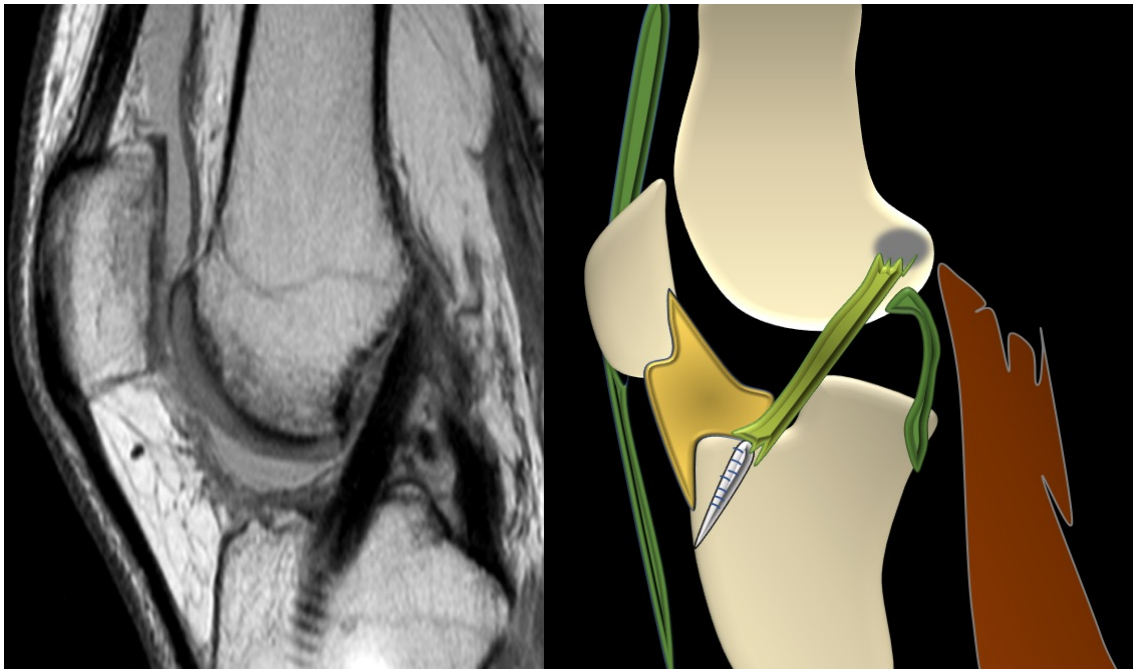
Sagittal T2W MRI of a 25-year-old male patient three years post ACL reconstruction showing the normal-appearing homogeneously hypointense ACL graft.
